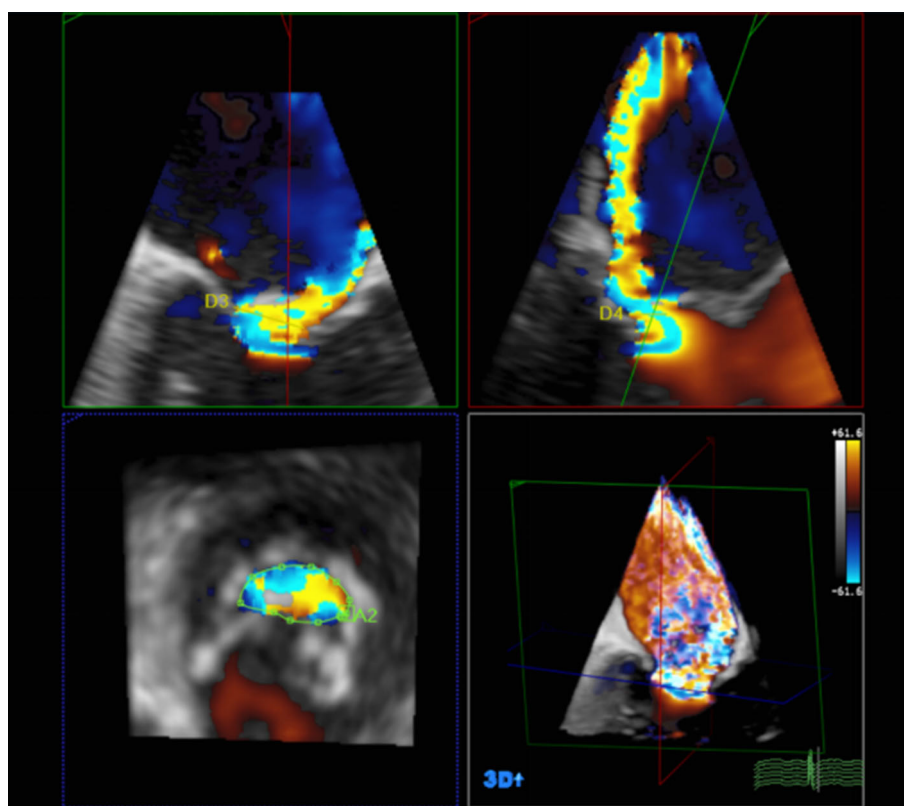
Transesophageal 3D-color assessment of vena contracta in a regurgitant mitral valve, showing its asymmetric shape
